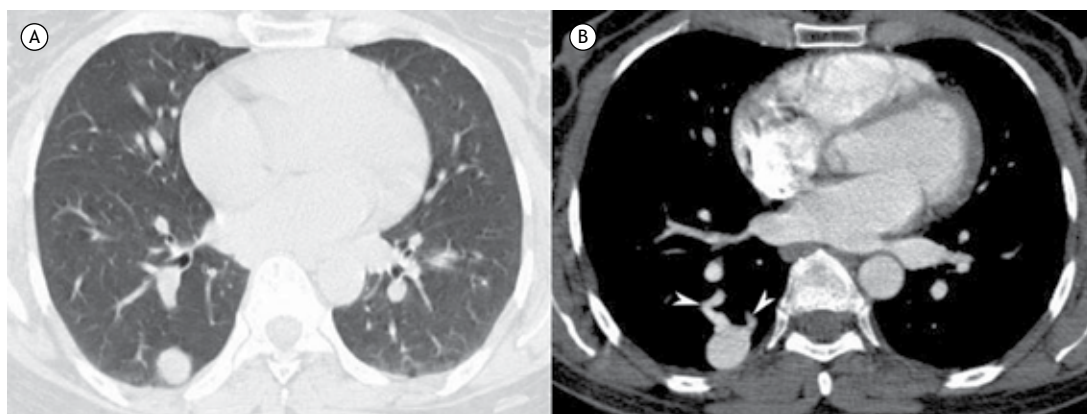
Chest CT displayed in lung (A) and mediastinal (B) windows shows a well-circumscribed nodule in the right lower lobe. In B, contrast enhancement reveals the presence of two vascular outlines (arrowheads) intimately related to the nodule, which correspond to the feeding artery and the draining vein.
